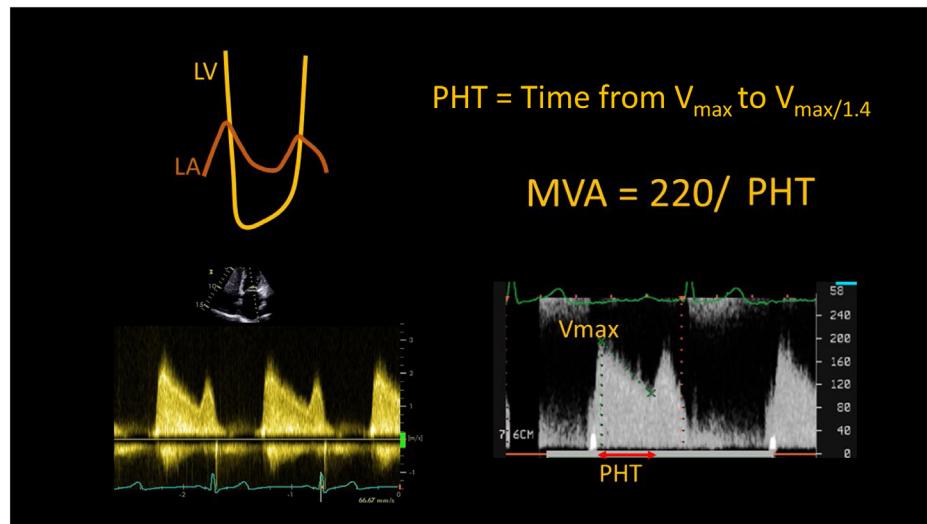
Overview of hemodynamic assessment of MS. MS results in increased left atrial pressure, shown in simultaneous LA and LV pressure tracings (upper left), resulting in increased transmural pressure gradient and velocities, seen in the continuous-wave Doppler waveform of mitral inflow (lower left). The mean gradient across the stenotic MV is measured from the transmural flow VTI. Elevated early inflow peak velocity (V_{max}) may be used to calculate PHT, which in turn yields calculation of mitral valve area (upper and lower right). LV, Left ventricle; LA, Left atrium; PHT, pressure half-time; MVA, mitral valve area.
